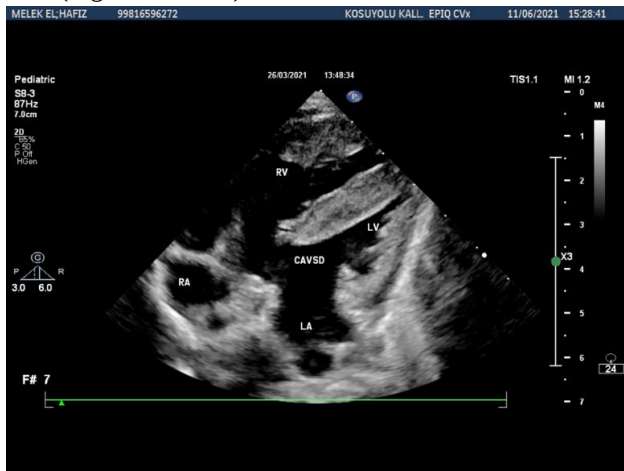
Echocardiographic imaging of atrioventricular septal defect, left ventricular hypoplasia, atrial septal defect, and absent pulmonary valve.
